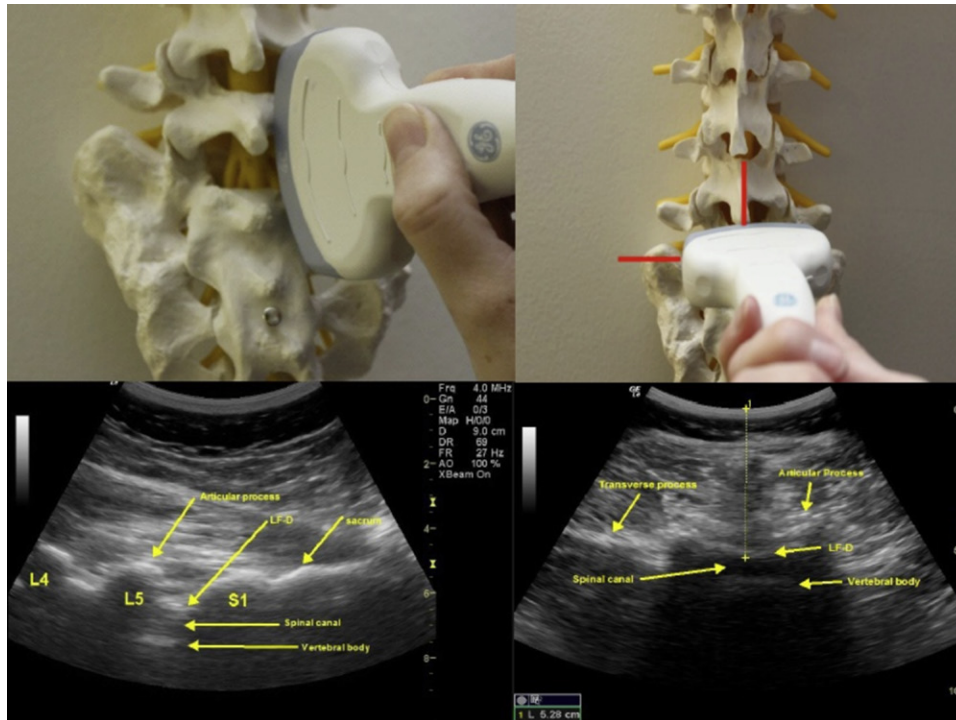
Orientation of ultrasound probe and identification of underlying structures.
